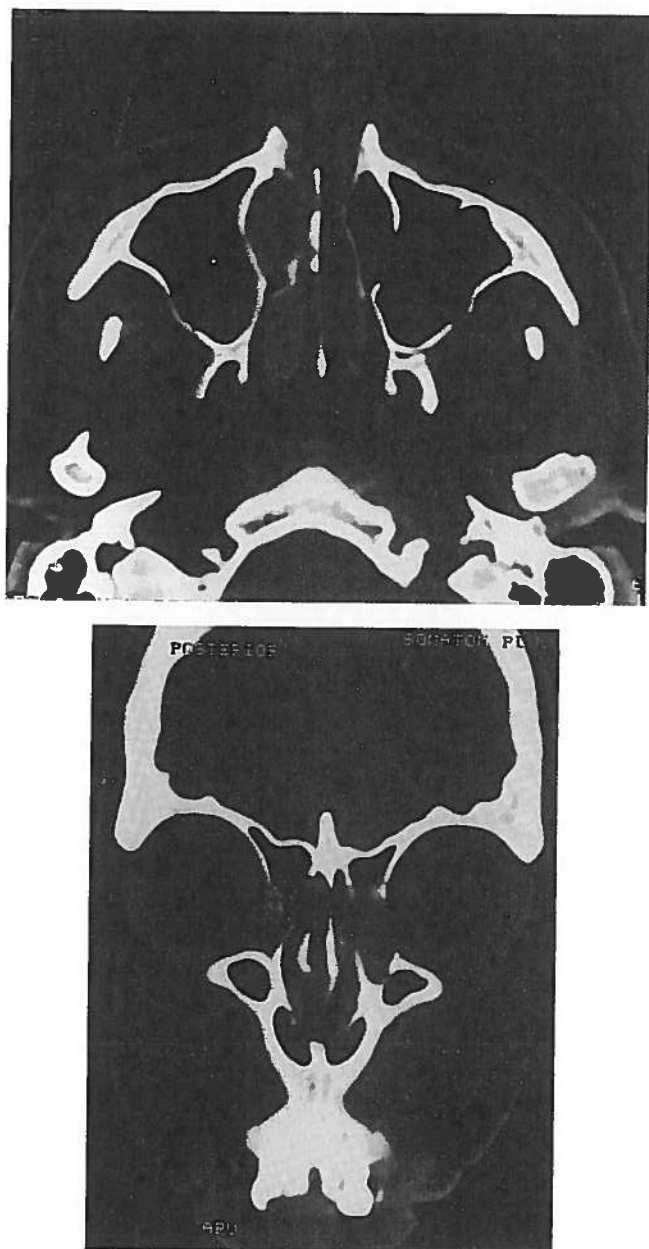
Axial (A) and coronal (B) CT-scan showing the tumour in the lacrimal sac and nasolacrimal duct extending in the nasal cavity.
